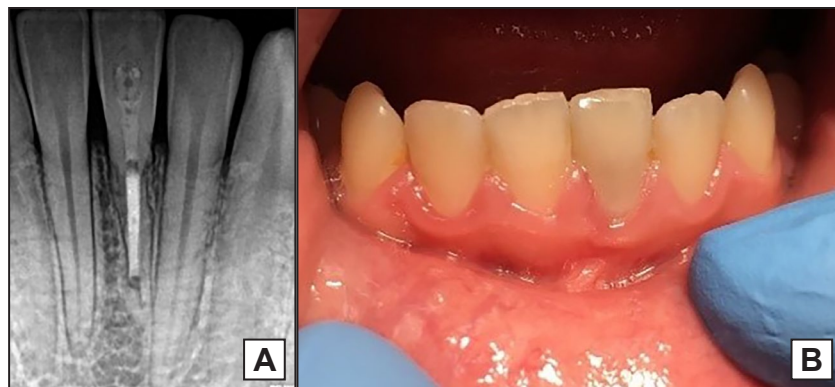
Follow-up after 5 years. A = periapical radiograph; B = intraoral photograph.
